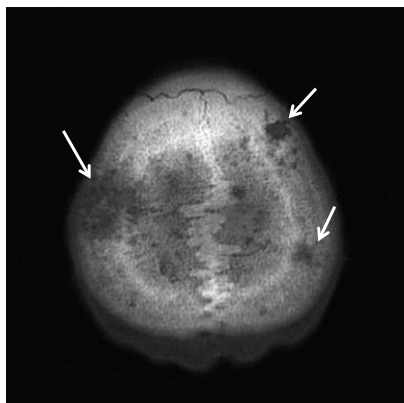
Brain CT (bone window) shows multiple infiltrating lesions in the cranial bones are indicated by the arrows.
